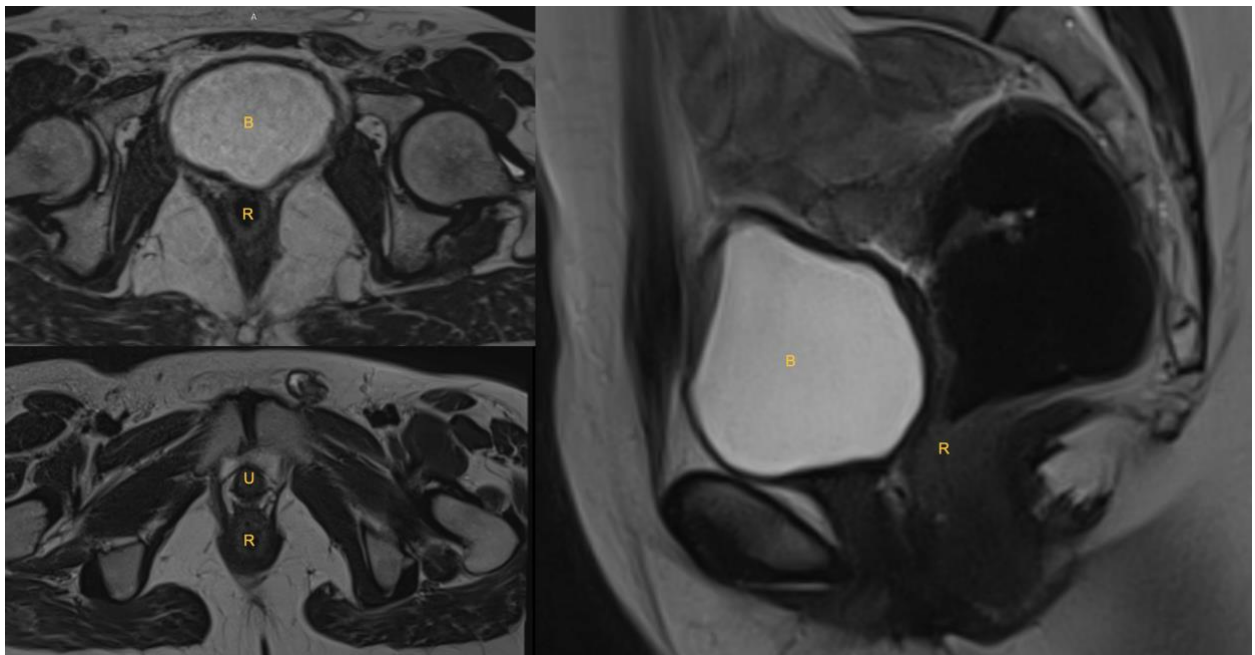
Pelvic MRI in axial and sagittal T2 weighted sequences demonstrating complete uterovaginal agenesis.
